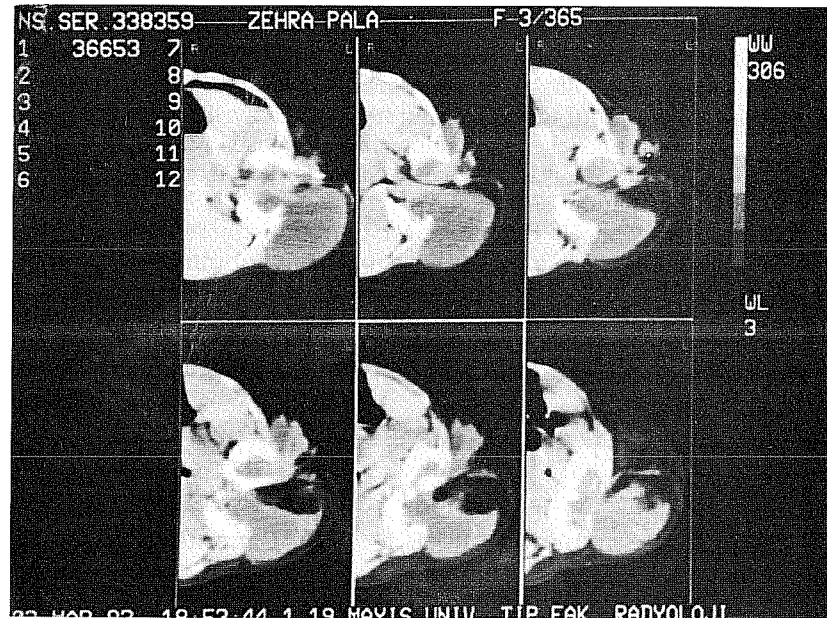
Contiguous CT slices at the thoracolumbar level show two separate CSF containing sacs, lipomas, bony spur splitting the spinal cord, and large cleft within the vertebrae. Each hemicord diverges extending to its own adjacent sac and lipomatous tissue.
